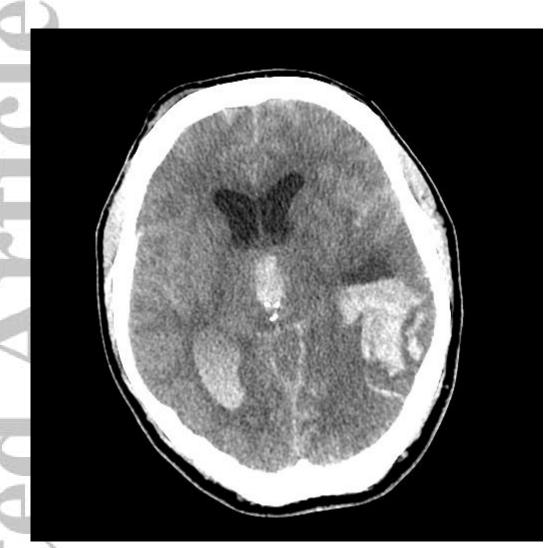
Admission CT head - Patient 1
